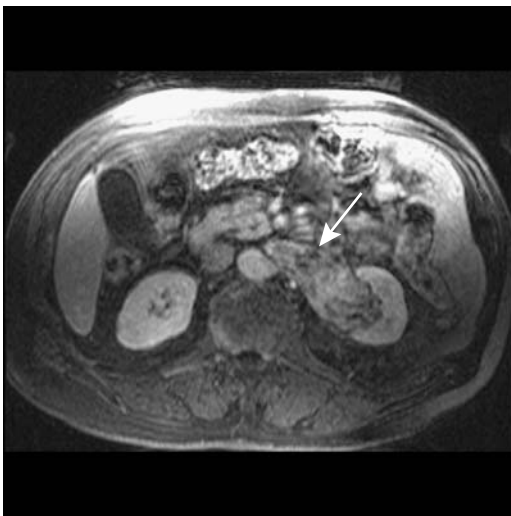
Transverse MR image reveals a left renal cell carcinoma with renal vein invasion (arrow). (Courtesy of Brian R. Herts, M.D., Cleveland Clinic Foundation.)
